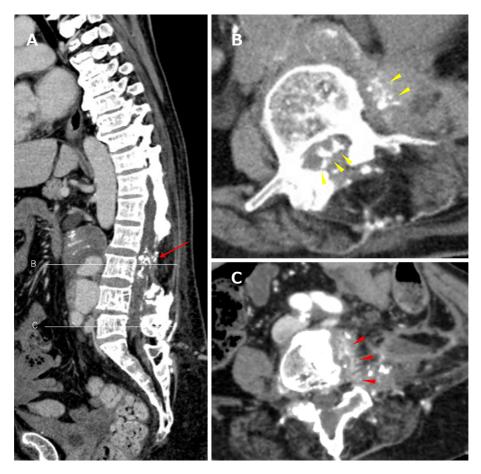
Contrast-enhanced whole-body computed tomography. (A) The sagittal image showed the postoperative changes in the Th12-L3 spinal canal (closed red arrows). (B) The axial image at the third lumbar body level showed erratic calcified lesions in the spinal canal and left paravertebral area (yellow arrowheads). (C) The axial image at the fifth lumbar body level showed bone destruction on the left side of the vertebral body with an abnormal contrast effect indicating vertebral hemangioma (red arrowheads).
